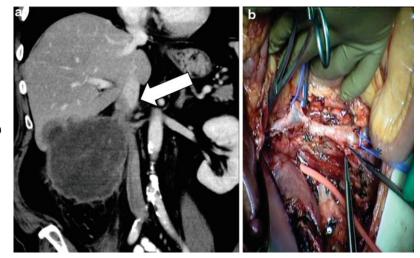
Advanced kidney tumors. CT scan (a) of large right-sided renal tumor invading the liver and vena cava with tumor thrombus extending into the vena cava (*arrow*). Surgical resection of the mass was performed (b) with reconstruction of the vena cava (*)
